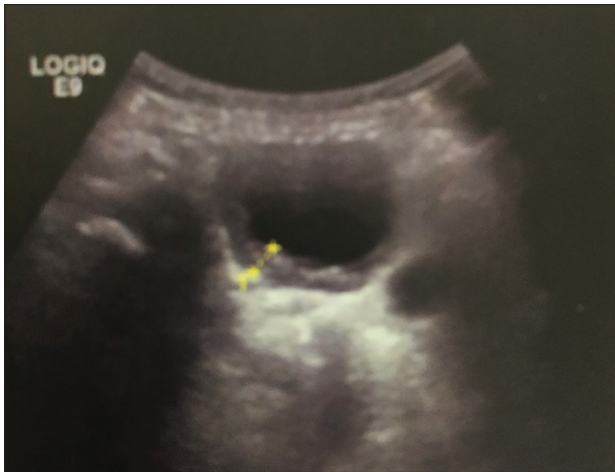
Thickened bladder wall in ultrasound
